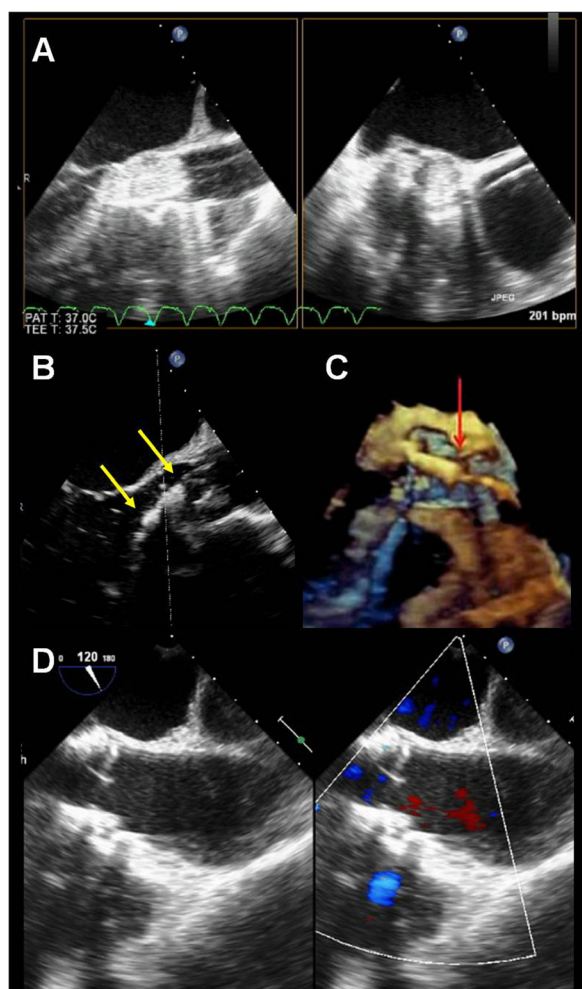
Intra-procedural guidance during TAVR. Transoesophageal echocardiography (TEE) permits real-time visualisation of the aortic valve, catheter and device. Using 3D TEE technique, simultaneous bi-plane images (of the standard long-axis and short-axis 2D TEE views) can be displayed during ballooning of the native aortic valve (A). To ensure correct transcatheter valve positioning, TEE allows visualisation of the proximal and distal margins of the transcatheter valve (yellow arrows in panel B). Live 3D TEE enhances the delineation between the valve stent and the delivery balloon, showing the upper margin of the transcatheter valve at the level of the sinus of Valsalva (red arrow in panel C). Immediately post-deployment, the position and function of the transcatheter valve is assessed, showing an example of a successful deployment of Edwards SAPIEN™ valve with no paravalvular leak (D) on colour Doppler TEE.
